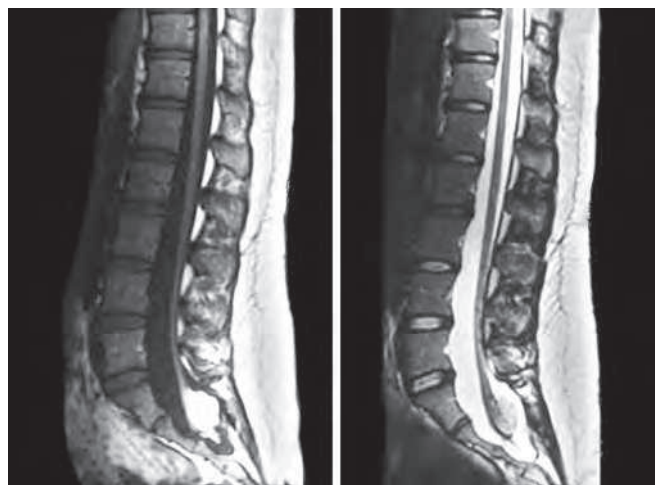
T1 (left) and T2 (right) magnetic resonance imaging of the lumbar spine demonstrating a lipomyelomeningocele, low-lying conus and tethered cord.
